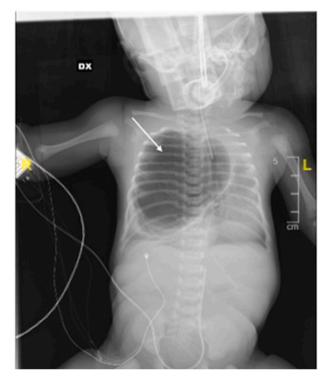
X-ray at birth (the cyst is indicated by the white arrow).
